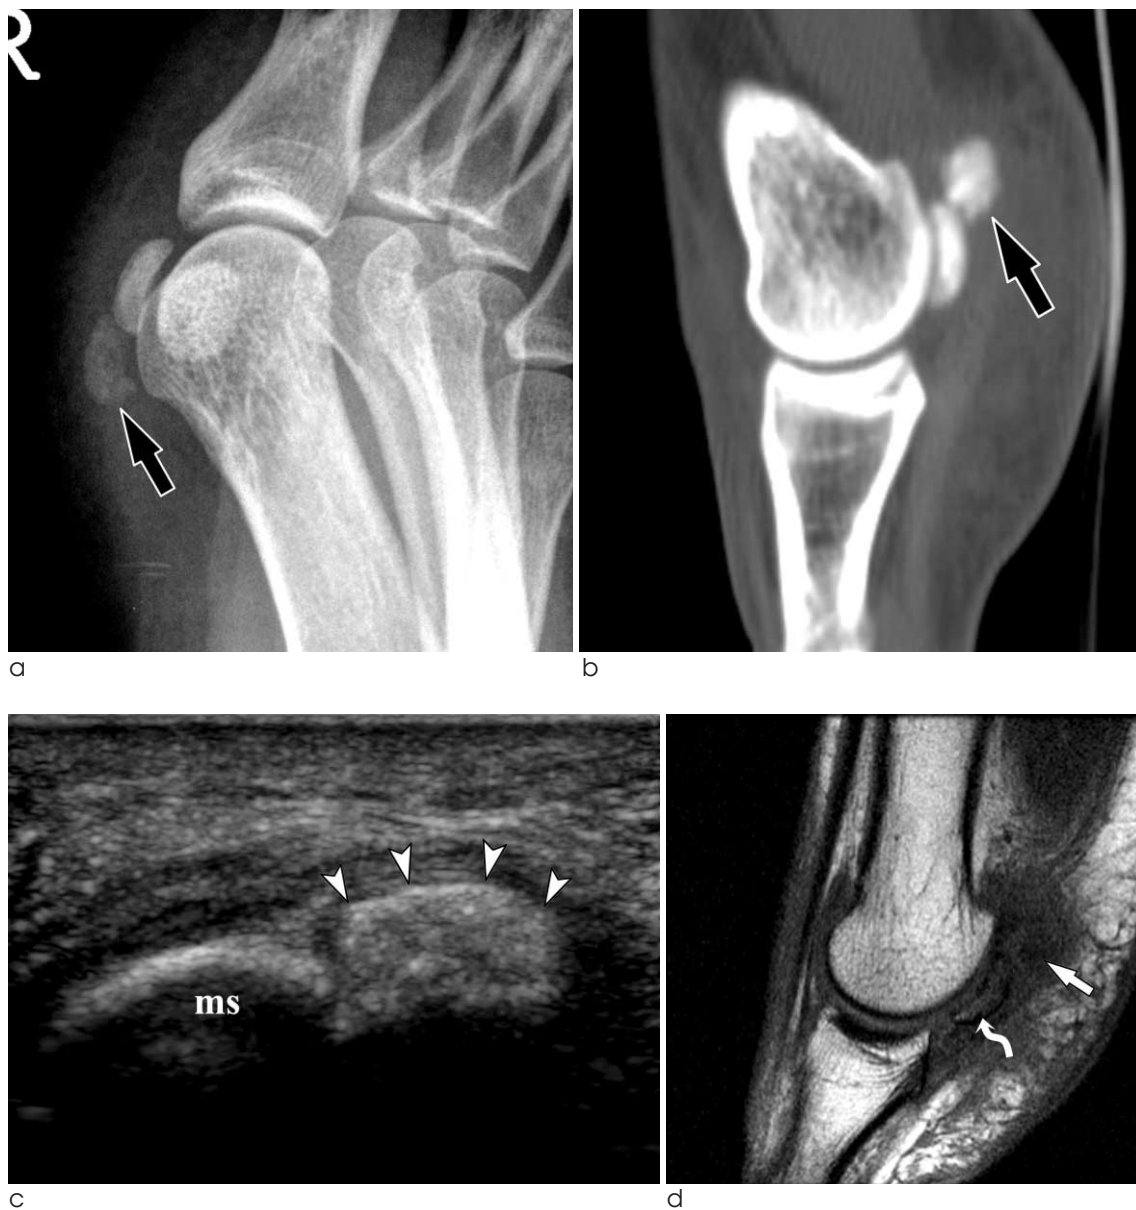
A 32-year-old woman with calcific tendinitis of the medial head of flexor hallucis brevis. Oblique radiograph (a) and CT with sagittal reconstruction (b) of the right first metatarsophalangeal joint show an amorphous calcification (arrow) adjacent to the medial sesamoid bone. c. US reveals an ovoid hyperechoic calcification (arrowheads) within the medial head of flexor hallucis brevis tendon. d. On sagittal T1-weighted MR image, calcification is seen as a faint low signal intensity nodule. Soft tissue edema is seen around the calcification and bone marrow edema is also seen in the medial sesamoid bone (curved arrow).
